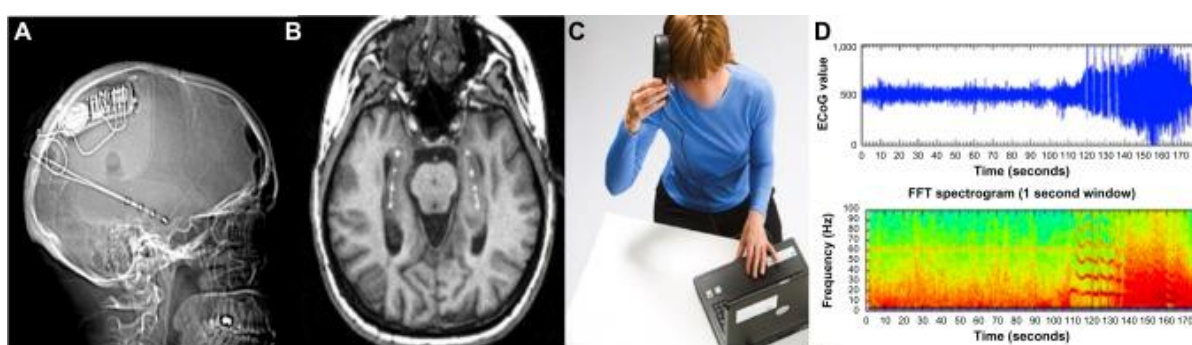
depicts the different components of the RNS system (9). (A) The RNS on skull X-ray. (B) Example of a bilateral hippocampal electrode implantation. (C) Interrogation of the device with the wireless wand and the programmer. (D) ECoG and time-frequency analysis from the device with detection of an epileptic seizure and stimulation delivered (vertical lines) (9)
